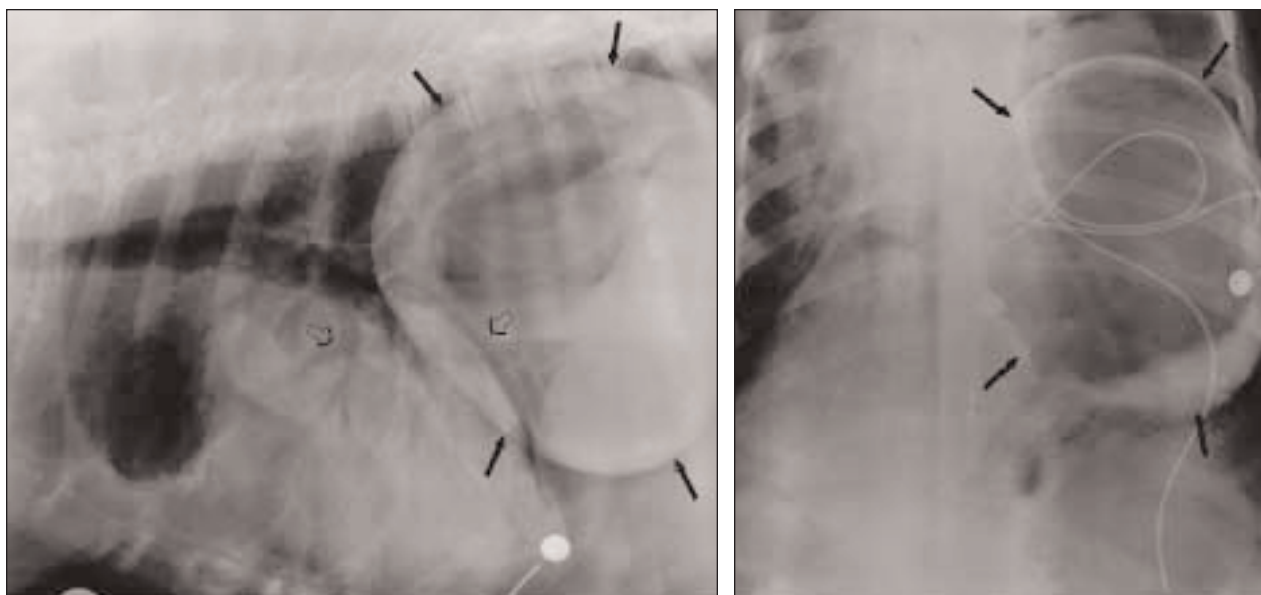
Same radiographic views as in Figure 1. Most of the stomach is within the caudal portion of the thorax and distended with gas (solid arrows). An alveolar infiltrate within the left cranial and caudal lung lobes is also apparent (open arrows).
